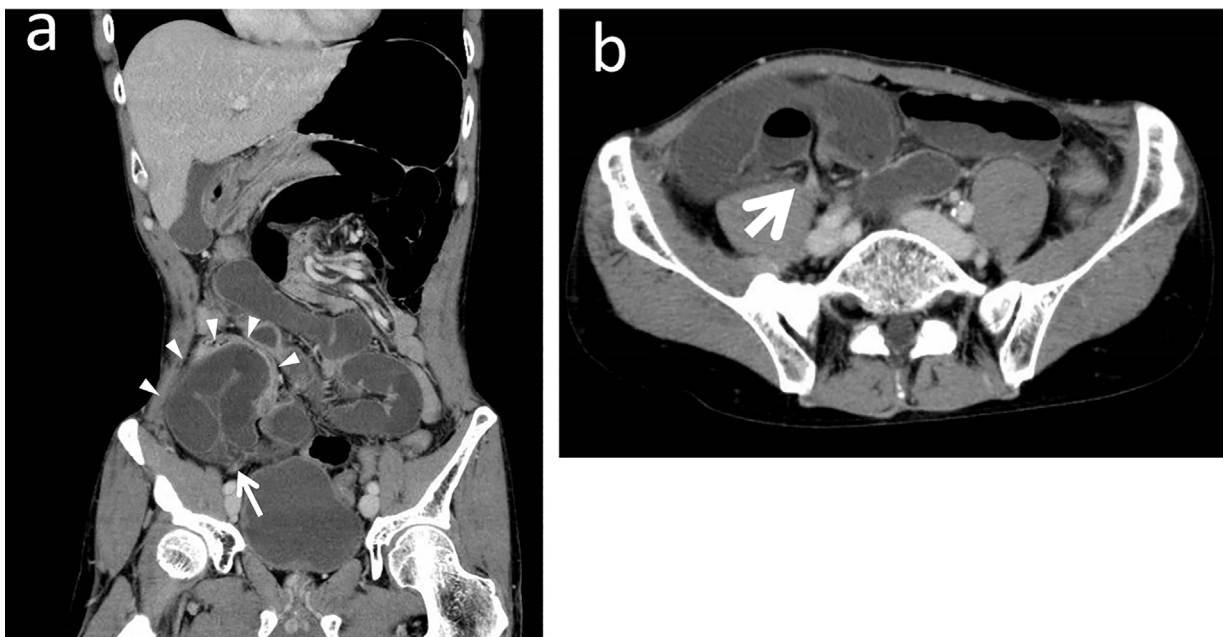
(a) An enhanced computed tomographic scan showed evidence of an intestinal obstruction at a paracecal site, with dilatation of the small intestine at the proximal side. The hernia sac (arrowheads) and defect (arrow) could be seen. (coronal image). (b) A change in the small intestinal caliber was seen around the cecum (axial image, arrowhead).
